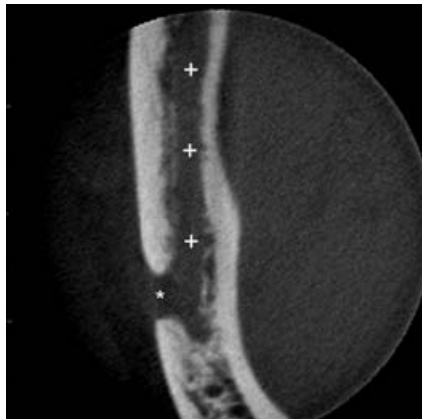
Axial CBCT slice
